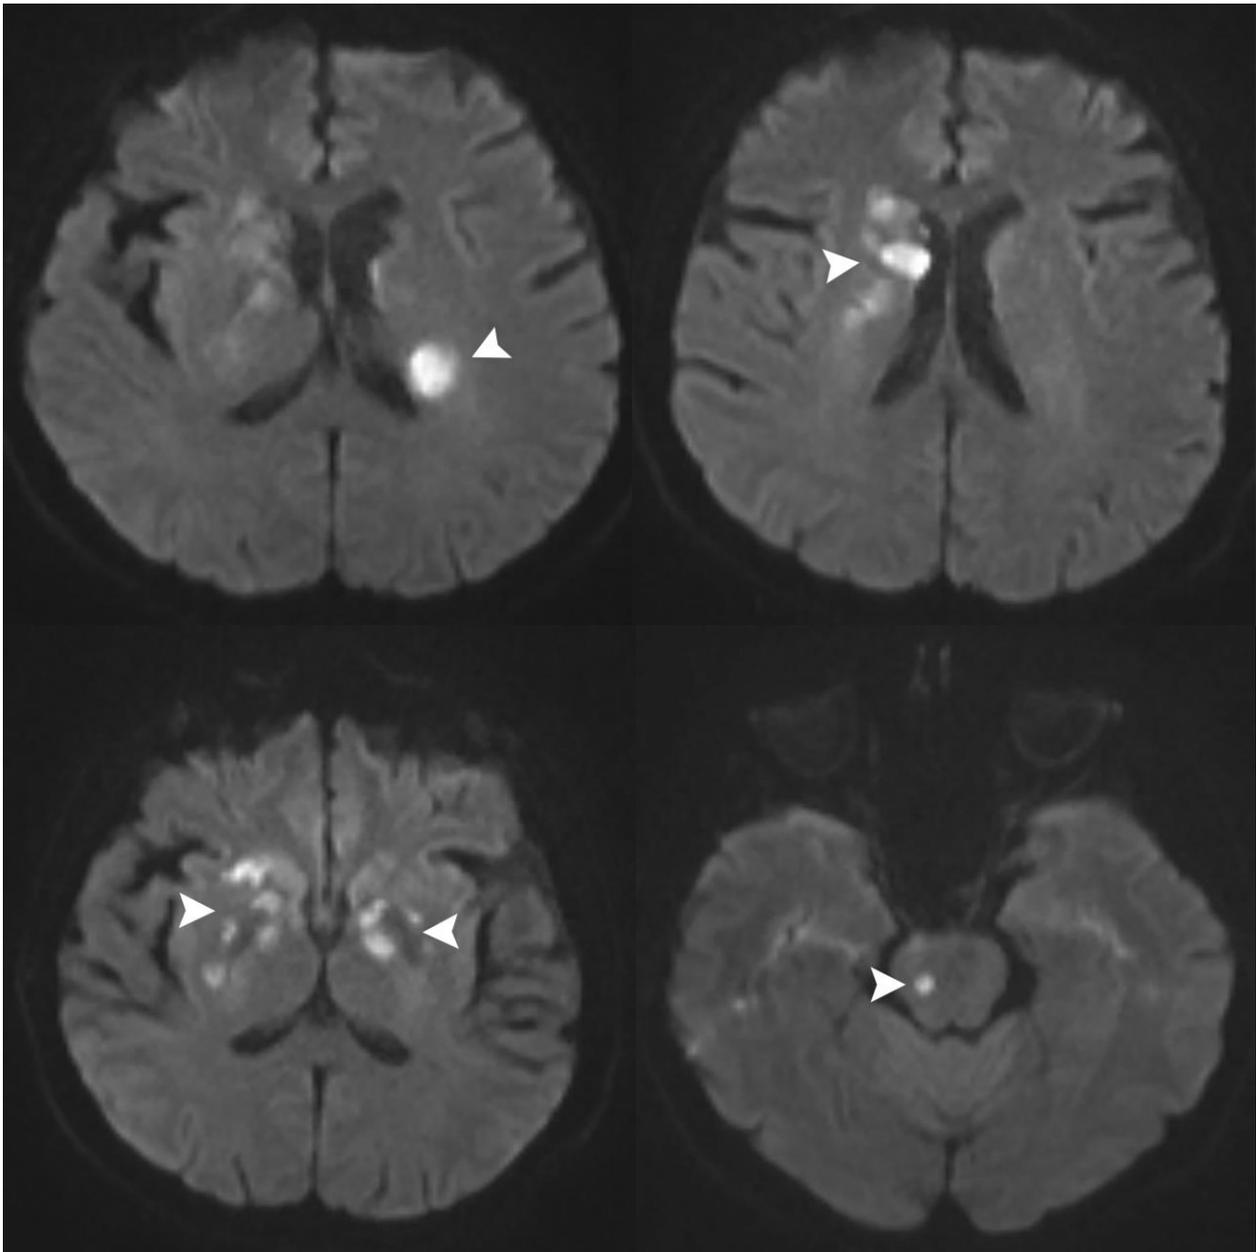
Brain MRI, axial DWI. Diffusion restriction in the 4A. Periventricular white matter, 4B and C. Basal ganglia and internal capsules, and 4D. Pons (arrowheads).
